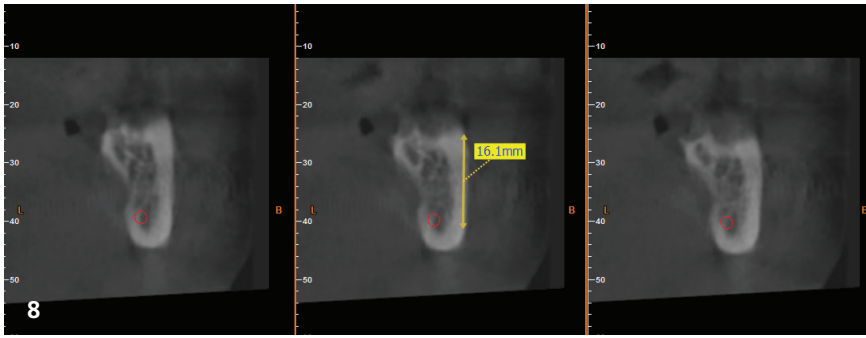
The digital CBCT scan demonstrates adequate clearance from the inferior alveolar nerve, thereby enabling an estimation of the maximum permissible length of the bone shell. In this instance, the regular-size Easy Bone Collector was employed, resulting in the generation of a bone shell measuring 15 mm in length and 7 mm in width.
